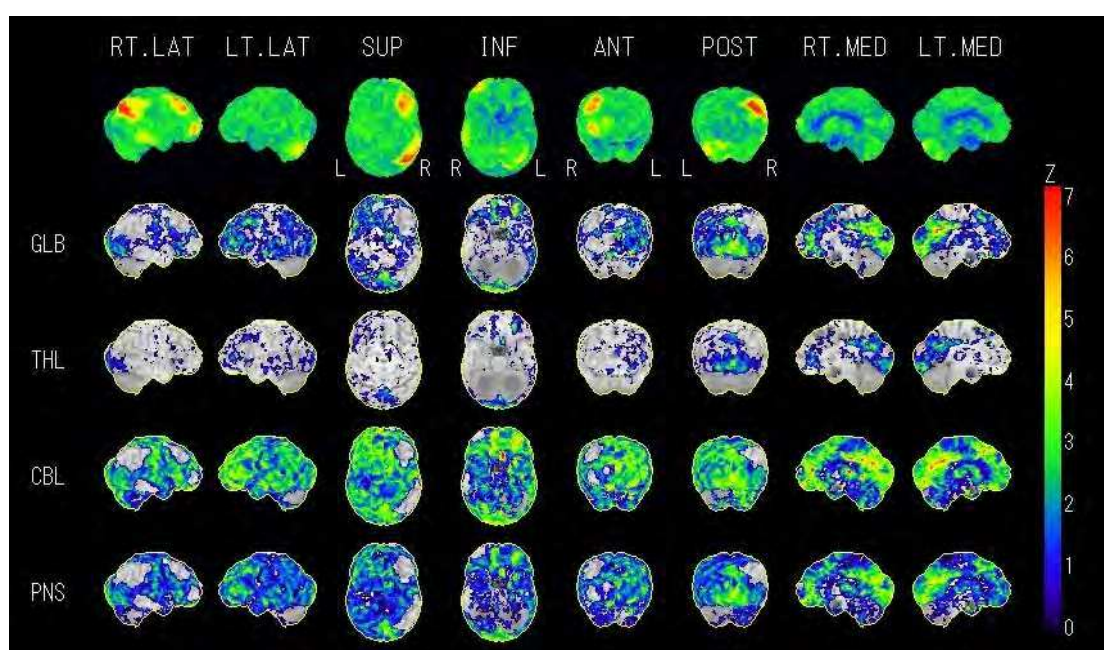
FDG-PET study of Creutzfeldt-Jakob disease. Hypometabolism and hypermetabolism are both present.
